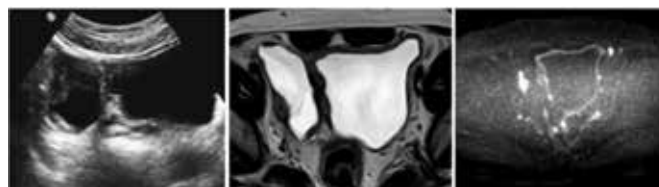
Male patient, 60 years old, with stage T2 urothelial carcinoma (a) ultrasound image of the right bladder diverticulum with intradiverticular soft tissue lesion. (b) intradiverticular mass on the right. (c) intradiverticular mass on the right.³
